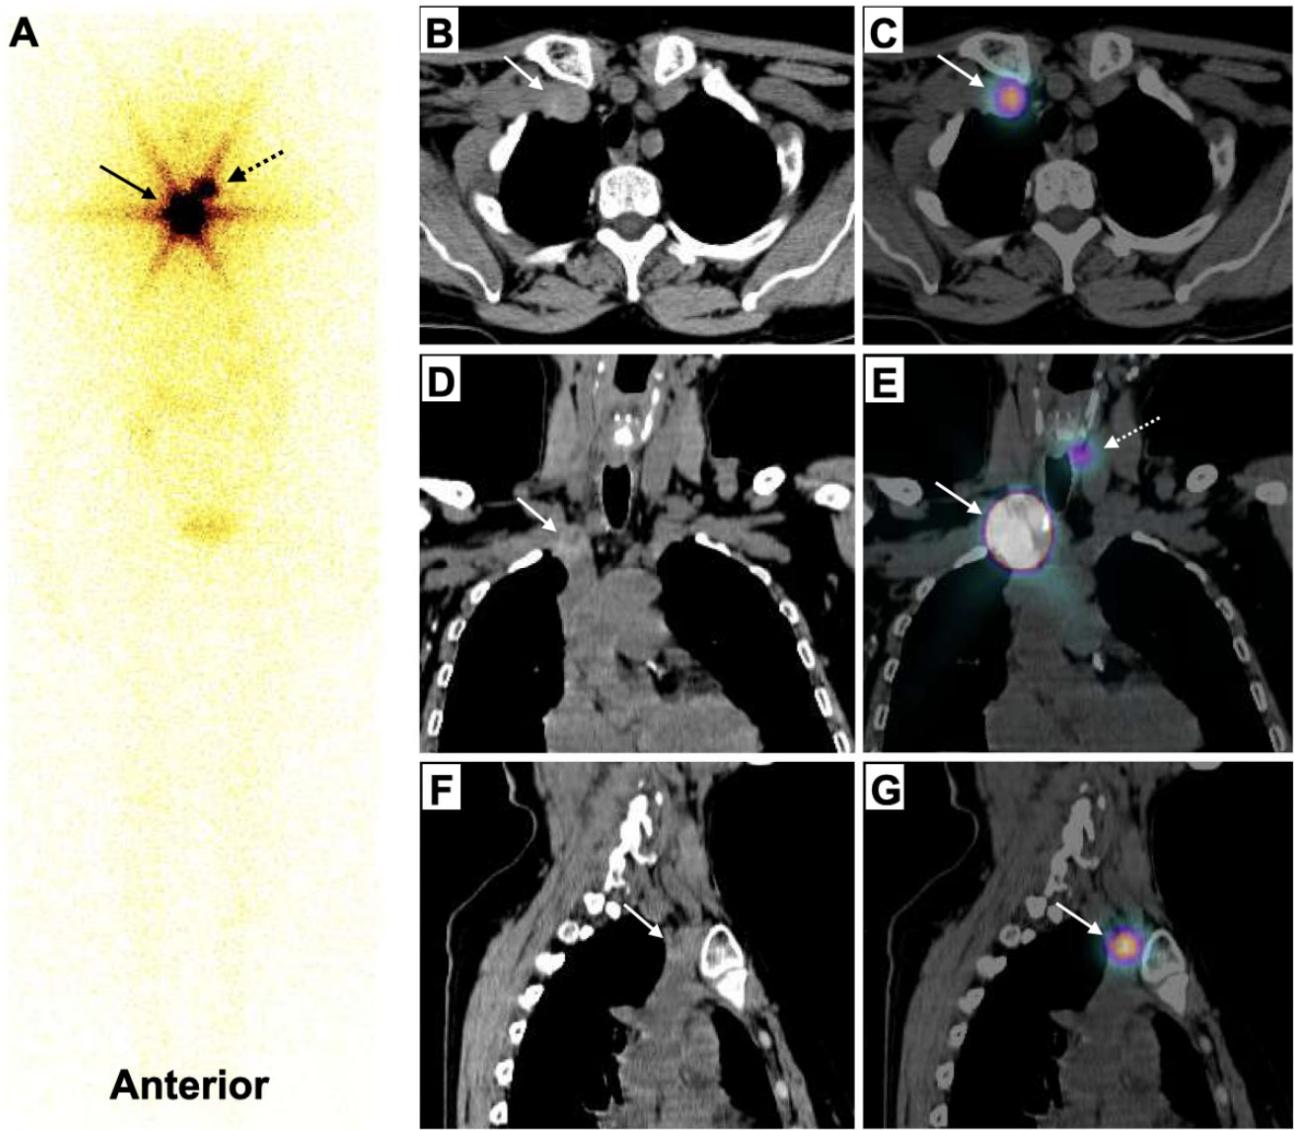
(A) Initial whole-body ^{131}I planar images on Siemens-Symbia T-series, showing focal tracer uptake in neck (dashed arrow) and intense focal tracer uptake in upper thorax (arrow). (B-G) CT and fused images showing tracer uptake in remnant (dashed arrow) and relatively hyperdense thrombus in right brachiocephalic vein (arrows).
